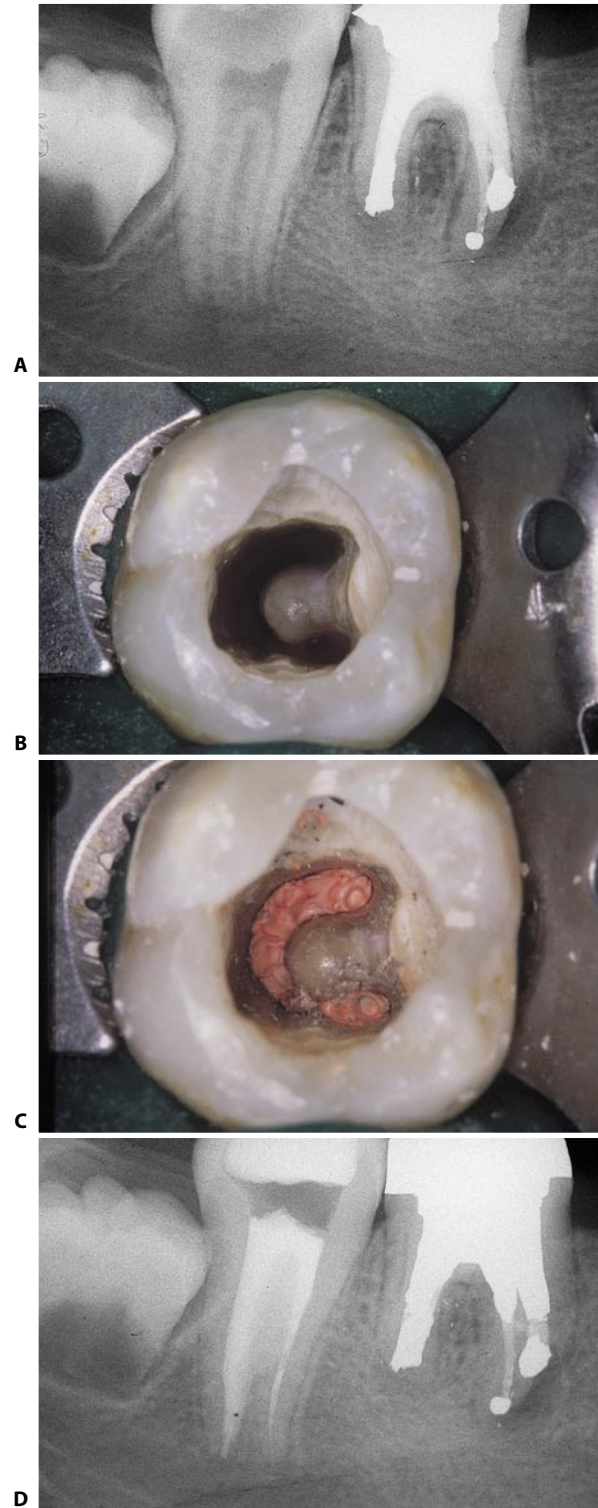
A lower right second molar with a C-shaped canal. A. Preoperative radiograph. B. Access cavity. Note the typical C-shaped appearance of the three connected canal openings. C. Three-dimensional obturation with warm gutta-percha has been completed. D. Postoperative radiograph. The C-shaped communication extends to the level of the apical one third.
